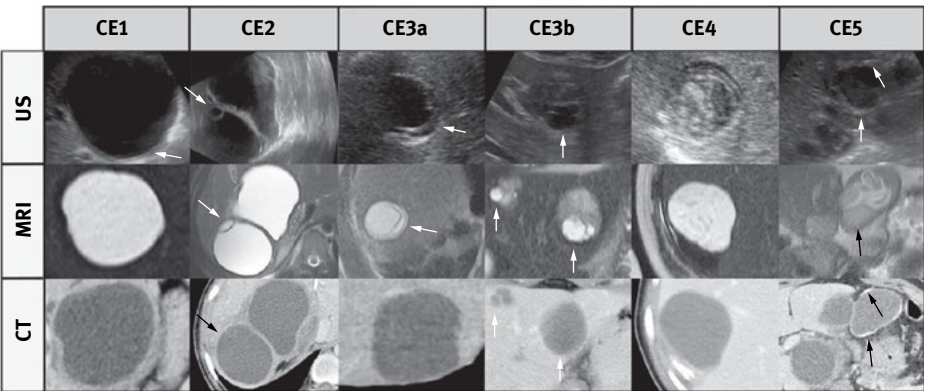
“Worst case” of CT/MR imaging. The “double line sign”, typical for CE1 is often seen in US (CE1/US, arrow), less reliably in MRI and CT. Daughter cysts and detached endocyst (“water-lily-sign”) is often missed by CTs, but clearly visible in US and MRI (see CE2, CE3a, arrows). Daughter cysts inside a solid cyst matrix are often not recognized by CT (CE3b, arrows). The CE4-specific canalicular structure is often not visible on CT images. These cysts may be misinterpreted as type CE1 cysts, i.e. staged “active” instead of “inactive”. The identification of calcifications is the domain of CT imaging. MRI does not differentiate well between thick hyaline walls and calcifications. US picks up calcifications only when a dorsal echo shadow is produced (see CE5, arrows). MRI: HASTE sequence, CT: post contrast enhanced images. doi:10.1371/journal.pntd.0001880.g005 [48]
